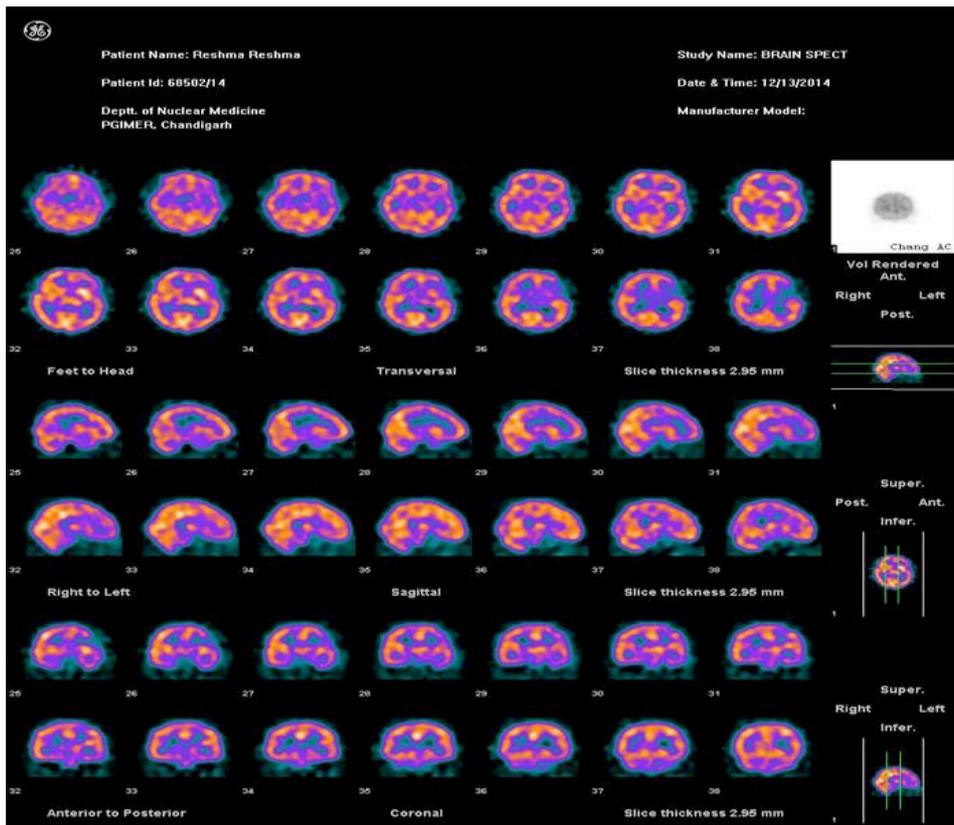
Pre-operative SPECT showing severely reduced perfusion in left frontal cortex
